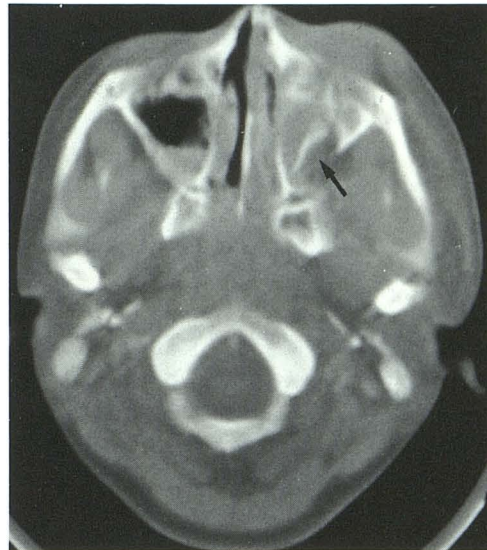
X-ray computed tomography scan. Fracture of the posterior wall of the left maxillary sinus (arrow) is clearly demonstrated.
